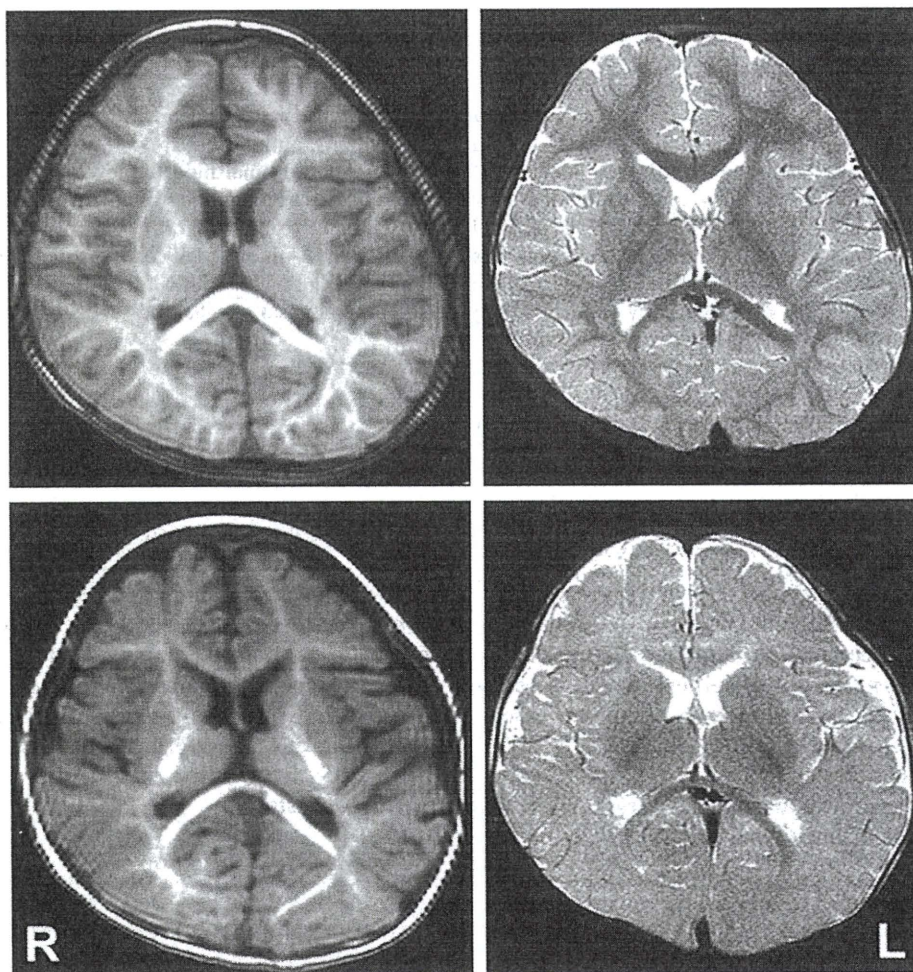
Axial T1-weighted (left) and T2-weighted (right) MRI at the level of the putamen. Upper row is patient 1 and lower row is patient 2. MRI shows a slightly small volume of the prefrontal areas in both patients. The volumes of basal ganglia and brain cortex are normal, and myelination is also normal. No abnormal intensity areas are seen.
